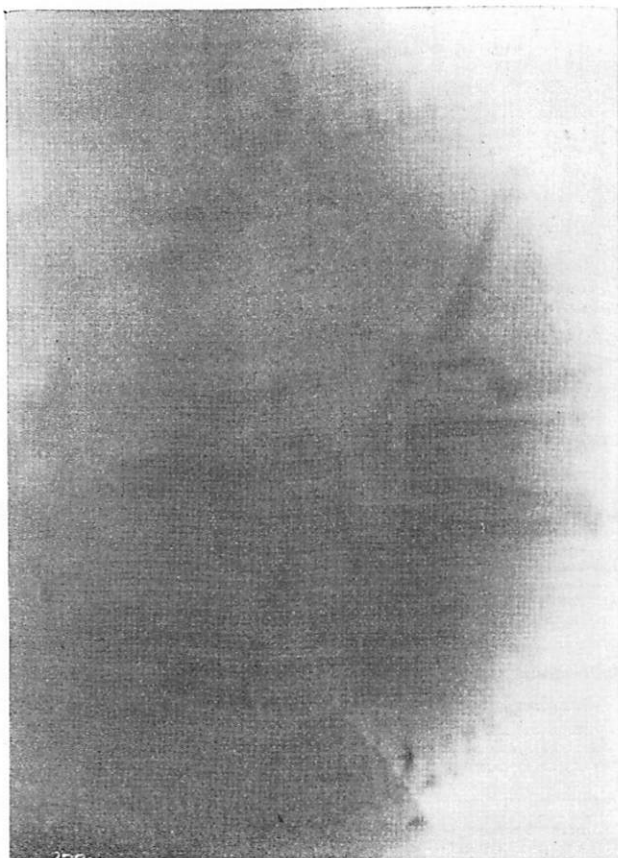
No. 3796, Mrs. T. Suspected twins, only one fetal heart heard. Roentgenogram in lateral position required to show twins.
